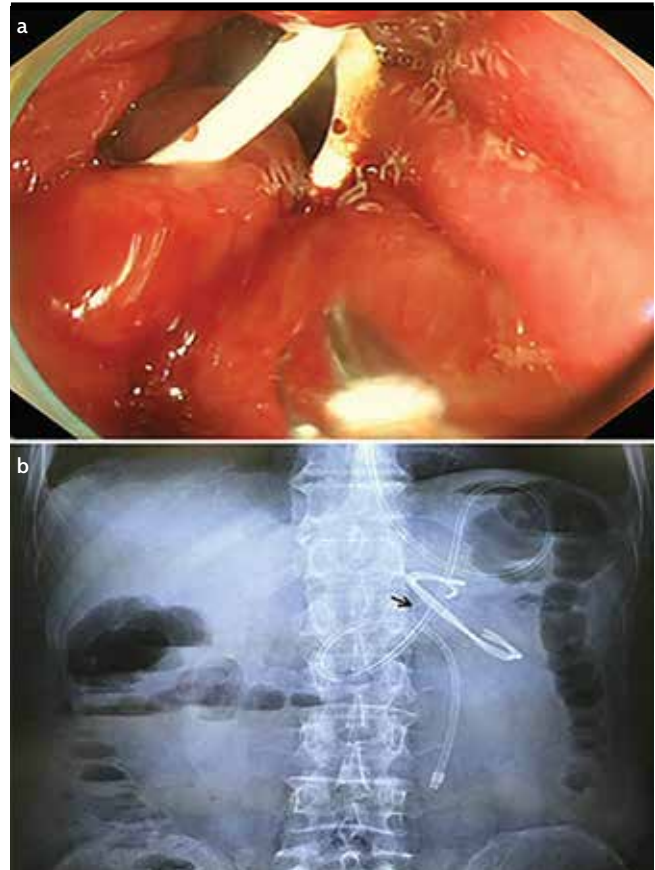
a, b. Implanted two pigtail stents: Two 7Fr-4cm double pigtail plastic stents (a); Annular anastomotic nail (black arrow, the two double pigtail stents across the gastrointestinal anastomosis and nasal feeding tube can be observed in the efferent loop under abdominal X-ray (b)
